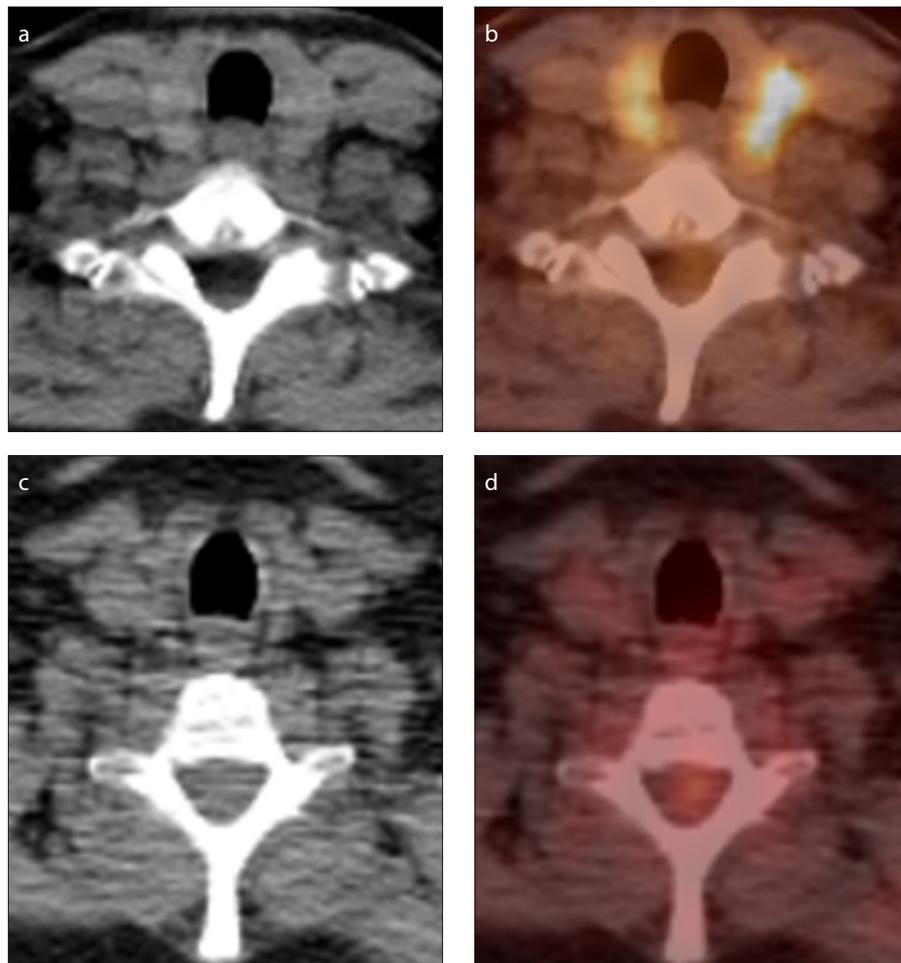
a, b. A 54-year-old woman with a history of melanoma. The patient received HDIL-2 therapy. Axial CT image of a restaging FDG-PET/CT scan (a) shows that the thyroid gland is normal in size. Axial fused FDG-PET/CT image (b) demonstrates diffusely increased FDG uptake within the thyroid gland, representing HDIL-2 related thyroiditis. Axial CT image of a restaging FDG-PET/CT scan obtained 21 months later (c) shows the atrophic thyroid gland. Axial fused FDG-PET/CT image (d) demonstrates resolution of metabolic activity in the thyroid gland.
